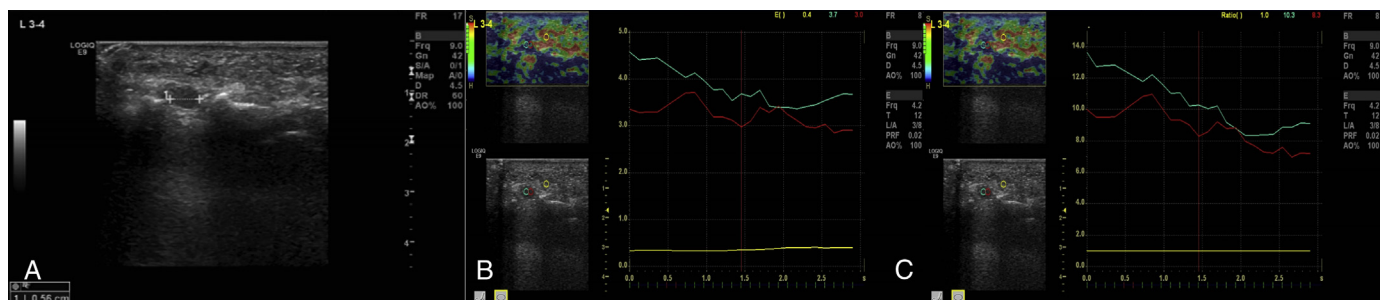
View of a 45-year-old female with metatarsalgia. (A) Coronal ultrasound image showing a well-circumscribed, ovoid, and hypoechoic mass lesion in the third intermetatarsal space of the left foot, consistent with Morton's neuroma. The mean elasticity of the 2 regions of interest was 3.35 (B), and the mean strain ratio was 9.3 (C). The lesion was slightly heterogeneous but appeared mostly blue on the color map.
